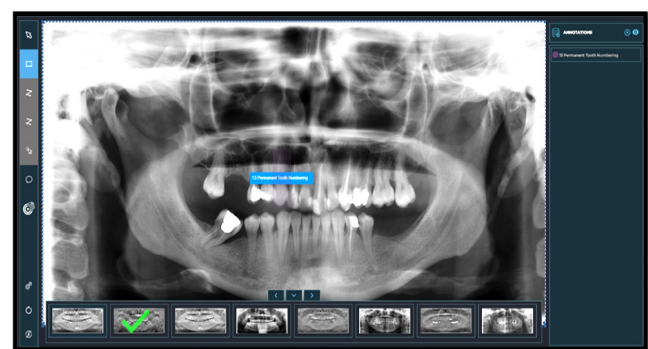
Example of "Area detection" data labeling for tooth detection and numbering in panoramic radiography.
